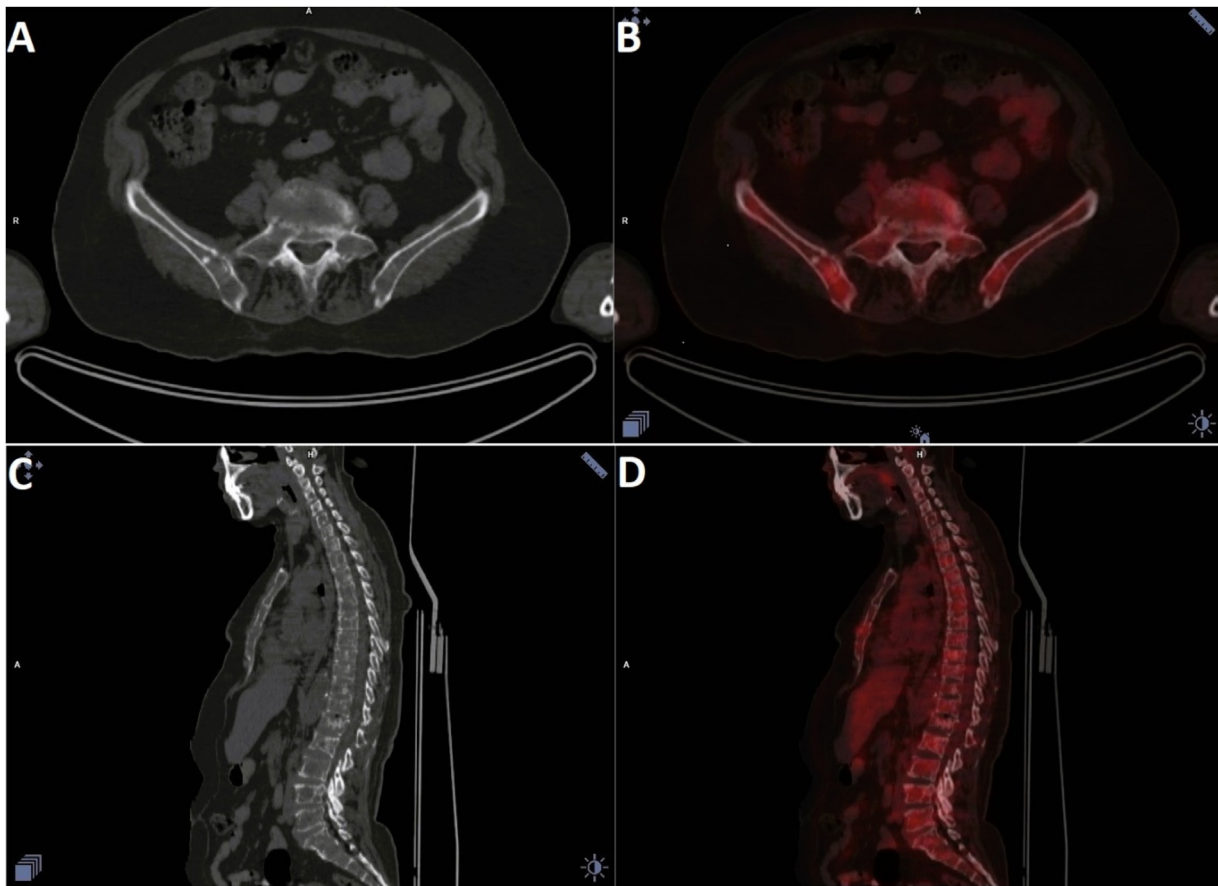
Axial CT (A), PET/CT fused images (B); Sagittal CT (C), PET/CT fused images (D) in a patient with diffuse bone marrow tracer uptake pattern. PET/CT fused images (B, D) showed diffuse increased FDG uptake in bones.
